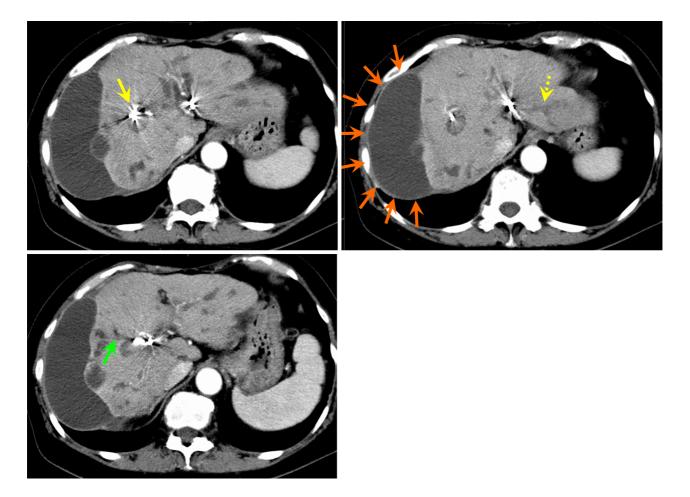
Contrast-enhanced computed tomography scan of the abdomen after aneurysm embolization. Diffuse atrophy was observed in the liver. The hepatic artery aneurysms in S 7/8 (yellow arrow), S 5 (green arrow), and the lateral segment (dotted yellow arrow) disappeared. The fluid collection on the surface of the right lobe of the liver (orange arrows) was thought to be a biloma caused by the rupture of a peripheral bile duct.
